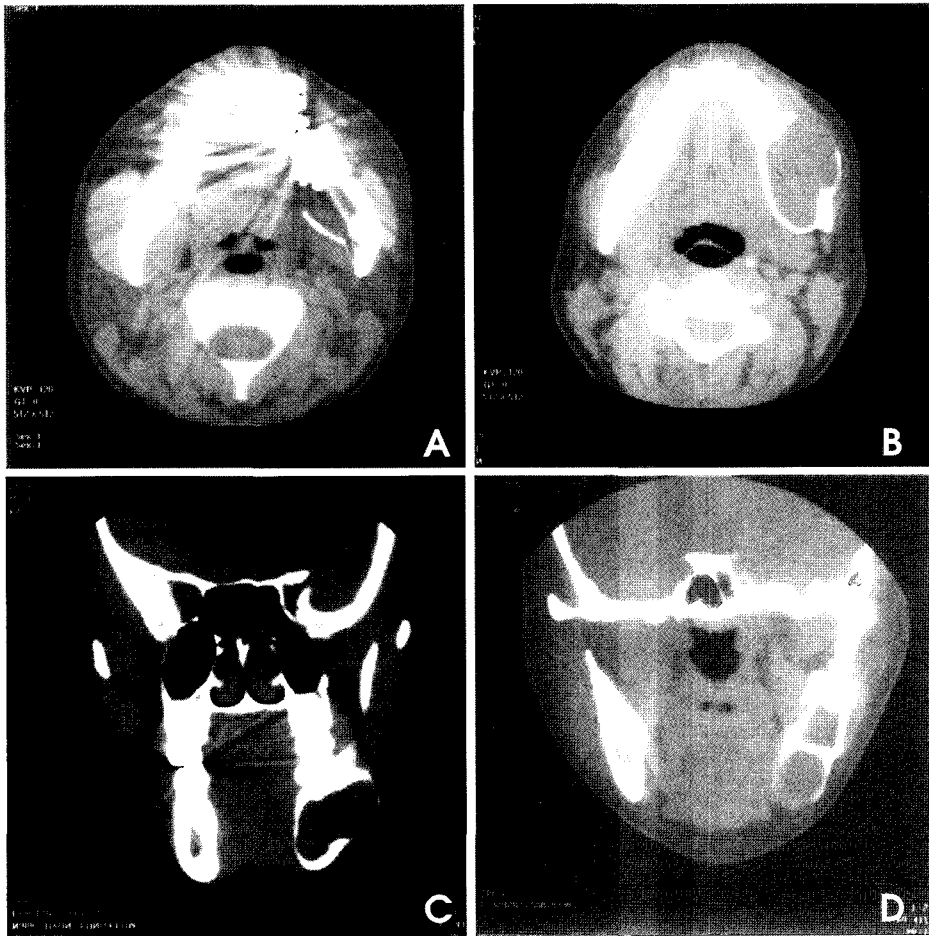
A, B, C, D. Axial and frontal computed tomographic images show bony expansion of the lingual and buccal cortex, with thinning and partial perforation and extension of the lesion into the buccal soft tissues.
